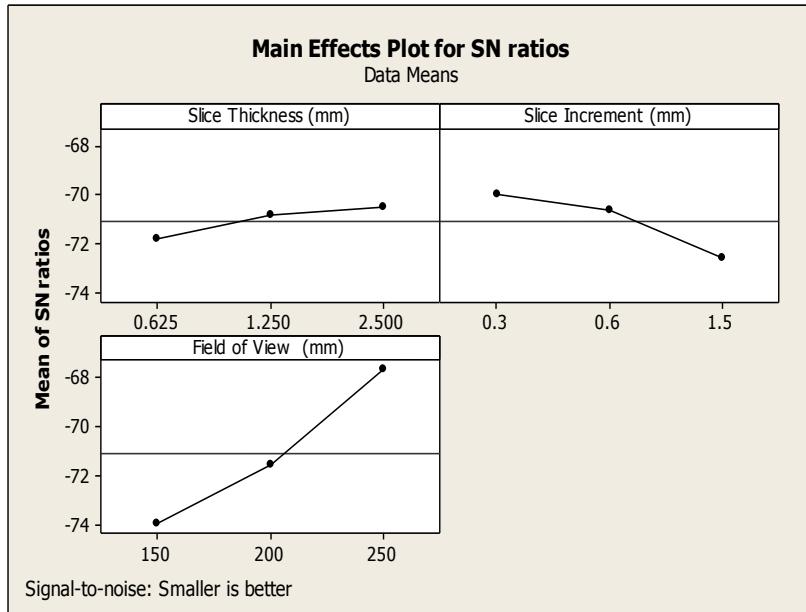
Effect of CT image construction parameters on volumetric error
